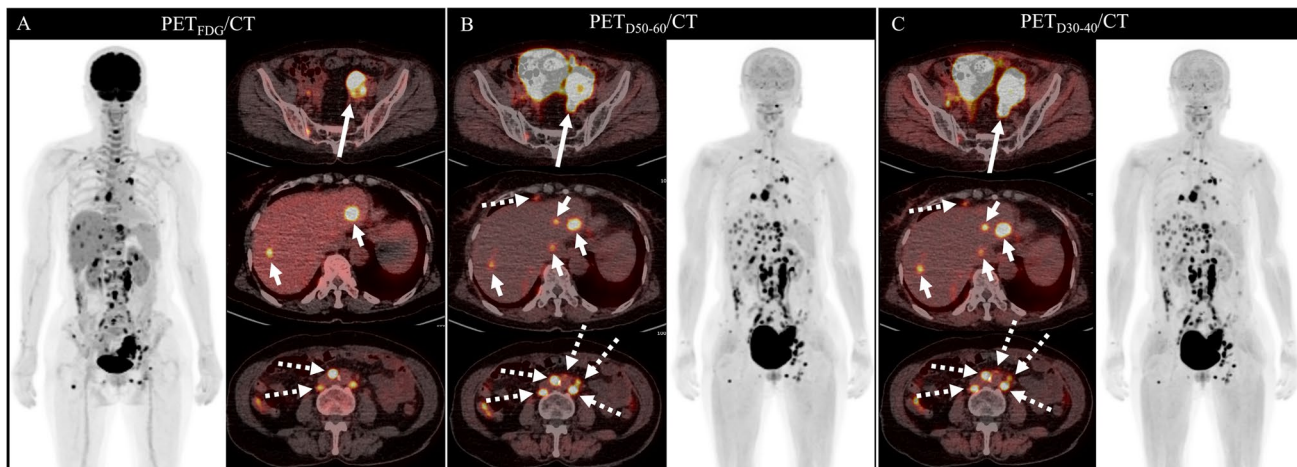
A 68-year-old woman with confirmed high-grad ovarian serous carcinoma underwent PET/CT for initial assessment. A Images from [¹⁸F]FDG PET/CT demonstrate intense tracer uptake in the left ovary (long arrow), accompanied by suspected liver metastases (short arrows) and retroperitoneal lymph-node metastases (dashed arrows). B Images from dual-tracer PET_{D50-60}/CT show equal tracer
